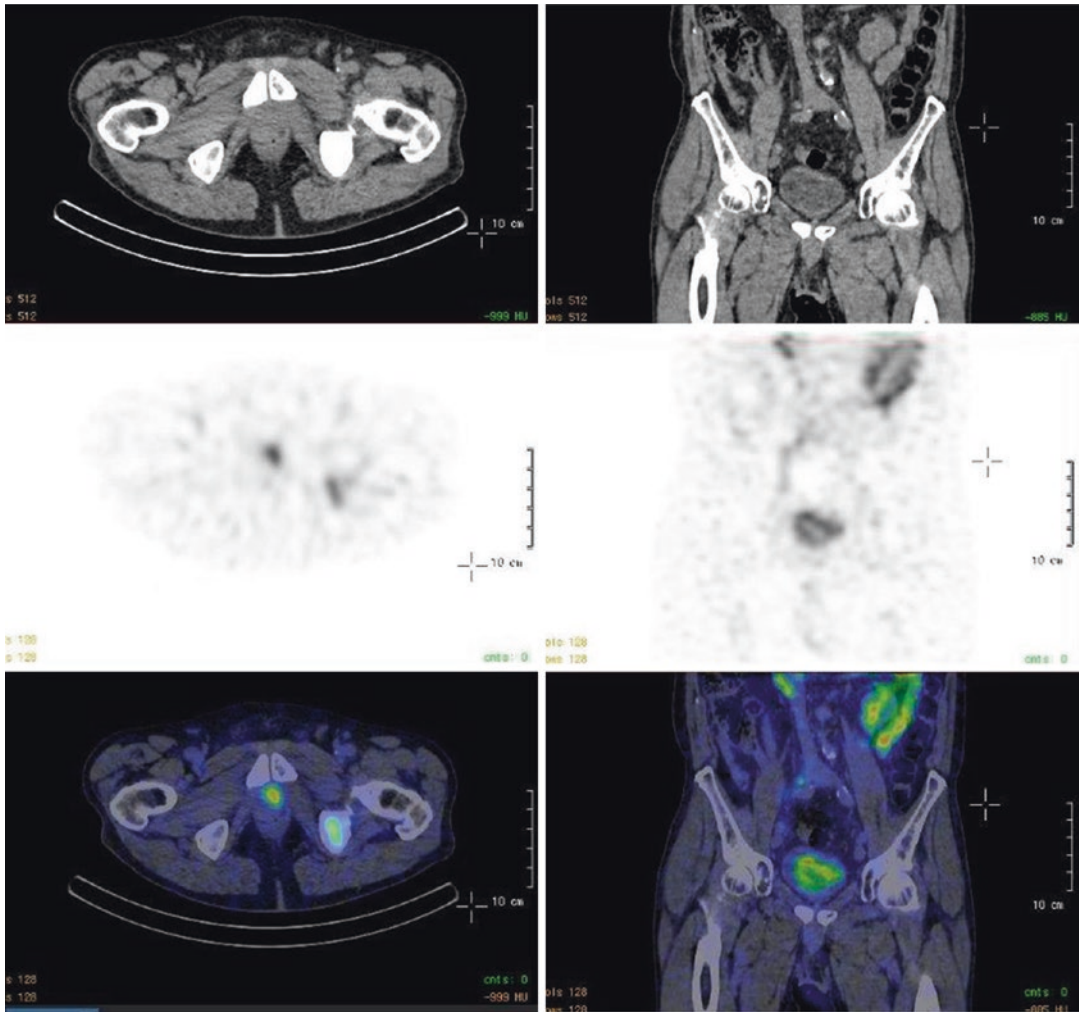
SPECT/CT images of Tc99m-PSMA show clearly a local relapse and bone metastasis in the pelvis, a small lymph node right to the aortal bifurcation is hardly
